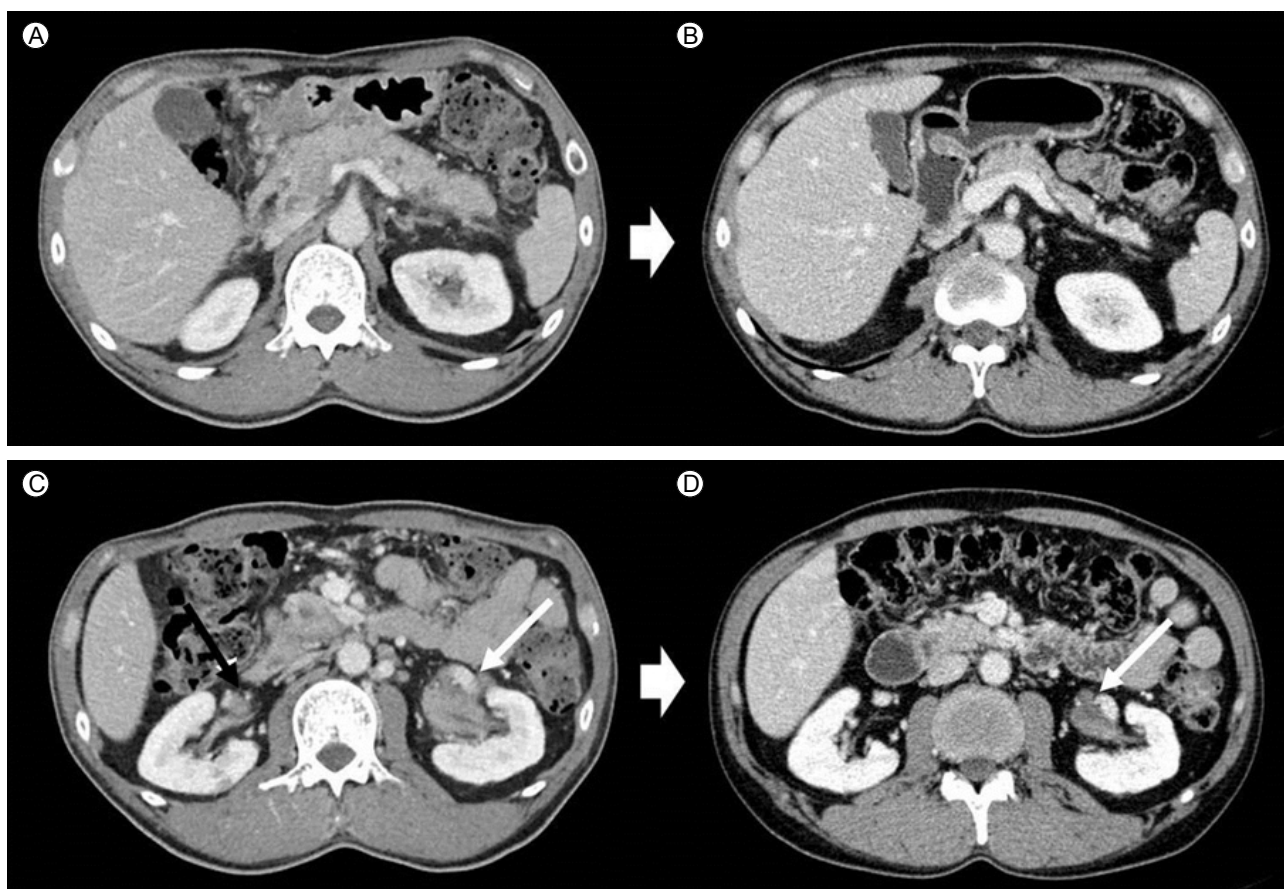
Follow-up CT scans at 12 months after oral steroid therapy. Compared with the initial images (A, C), pancreatic swelling and the cystic lesion in the tail portion are markedly improved (B), the left renal mass shows decreased size (white arrow), and the right renal pelvic mass has disappeared (black arrow) (D).
